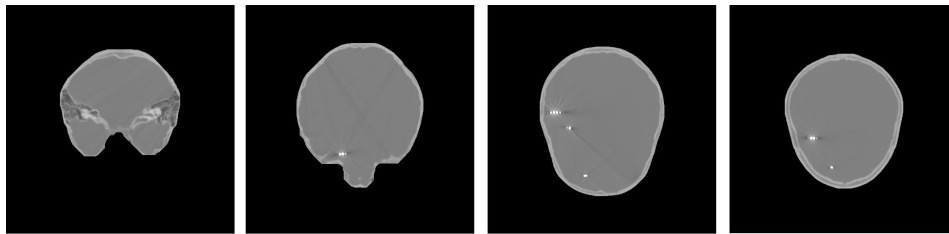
CT image slices after skull stripping.
